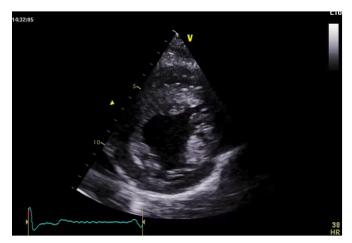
Transventricular short-axis ultrasound section showing hypertrophy of the walls of the left ventricle
